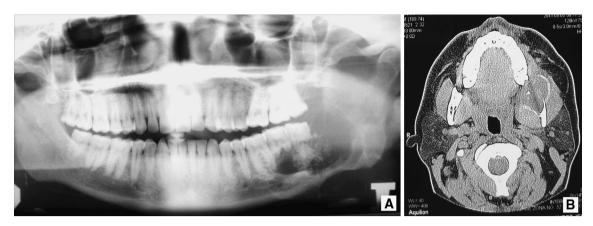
a Orthopantomogram. Unilocular mixed radiopaque/lucent, expansile and locally aggressive lesion, located in the left posterior mandible and ascending ramus; b CT. Osteolytic lesion is seen with expansion of surrounding tissue and a central area isodense to bone
